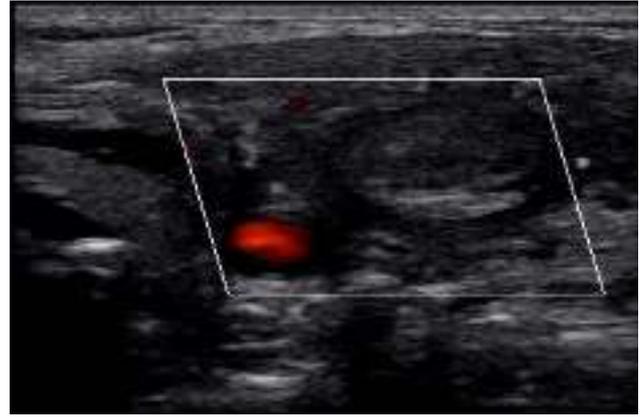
Doppler ultrasonography of left jugular vein
